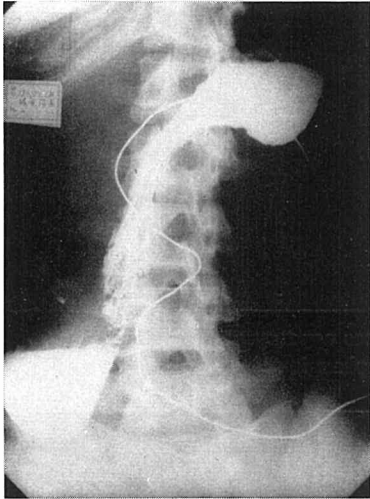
Barium study roentgenogram of upper gastrointestinal tract showing marked displacement of the stomach and duodenum due to the tumor mass.
